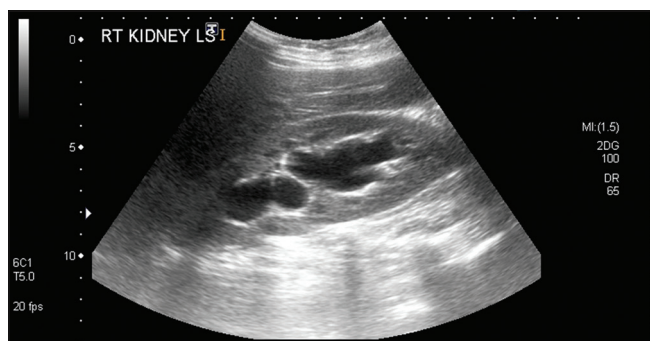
Ultrasonography of abdomen and pelvis showed moderate right hydronephrosis
